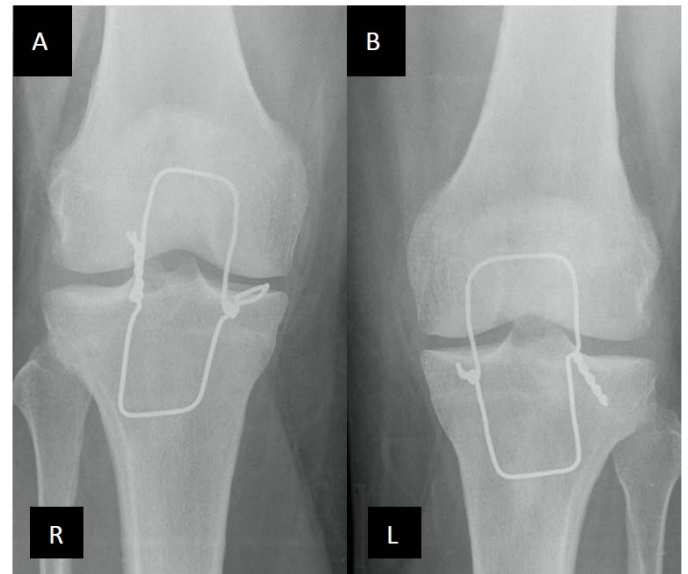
(A&B). Postoperative radiographs showing restoration of the patella level.
